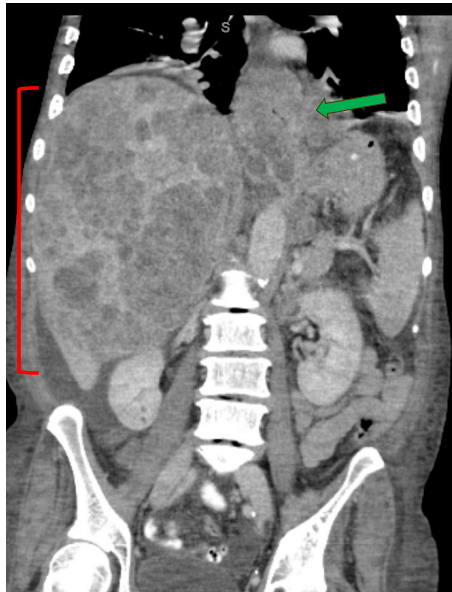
CT scan demonstrating primary esophageal neuroendocrine carcinoma tumor (green arrow) and extensive liver metastases (red bracket).
